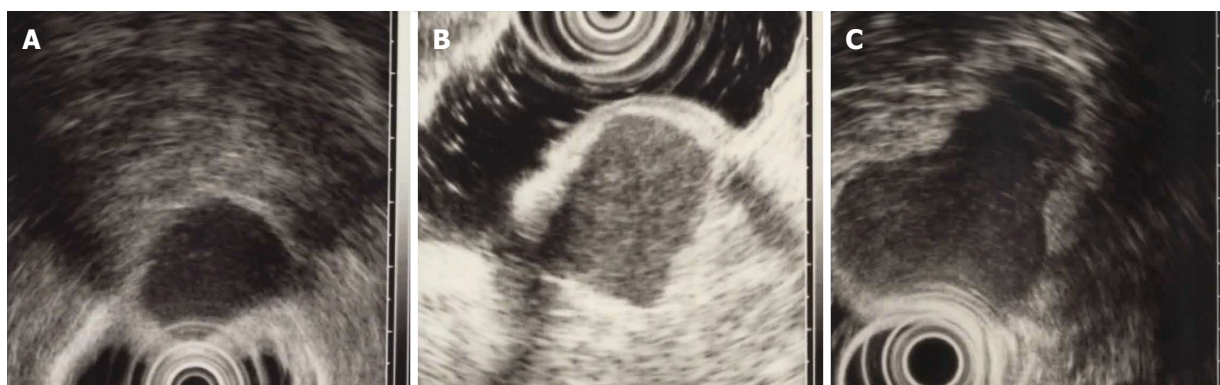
Gastrointestinal submucosal tumors high grade: Doubling time is 3.0 mo. A: EUS finding at baseline, tumor diameter is 25.5 mm; B: EUS finding at 6 mo later, tumor diameter is 28 mm; C: EUS finding at 12 mo later, tumor diameter is 38.5 mm. There are remarkable changes in one year. EUS: Endoscopic ultrasound.
